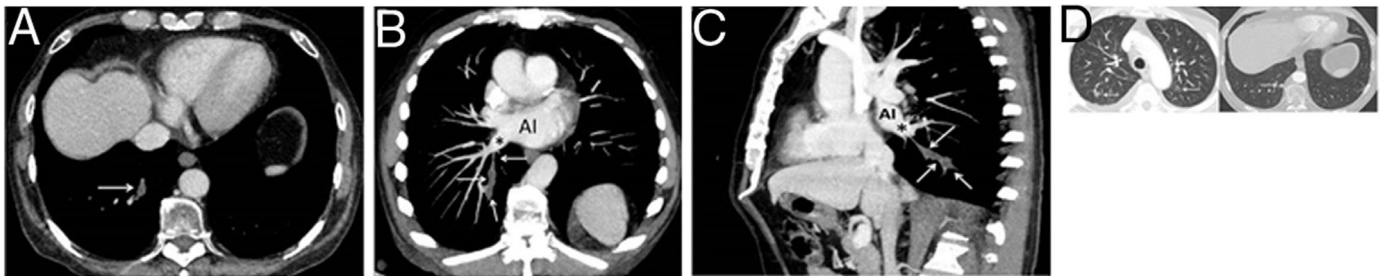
A) Axial chest CT image showing a tubular opacity in the posterior-basal segment of the right lower lobe corresponding to a large filling defect in the pulmonary vein of that segment (arrow). B and C) Oblique coronal (B) and sagittal (C) reconstructions of the chest CT (maximum intensity projection images) in which the continuity of the thrombosed vein (arrow) to the right inferior pulmonary vein (asterisk) and the left atrium (AI) can be best identified. D) Chest axial CT images (pulmonary parenchyma window at the aortic arch and bases) showing small bilateral parenchymal opacities (arrows).
